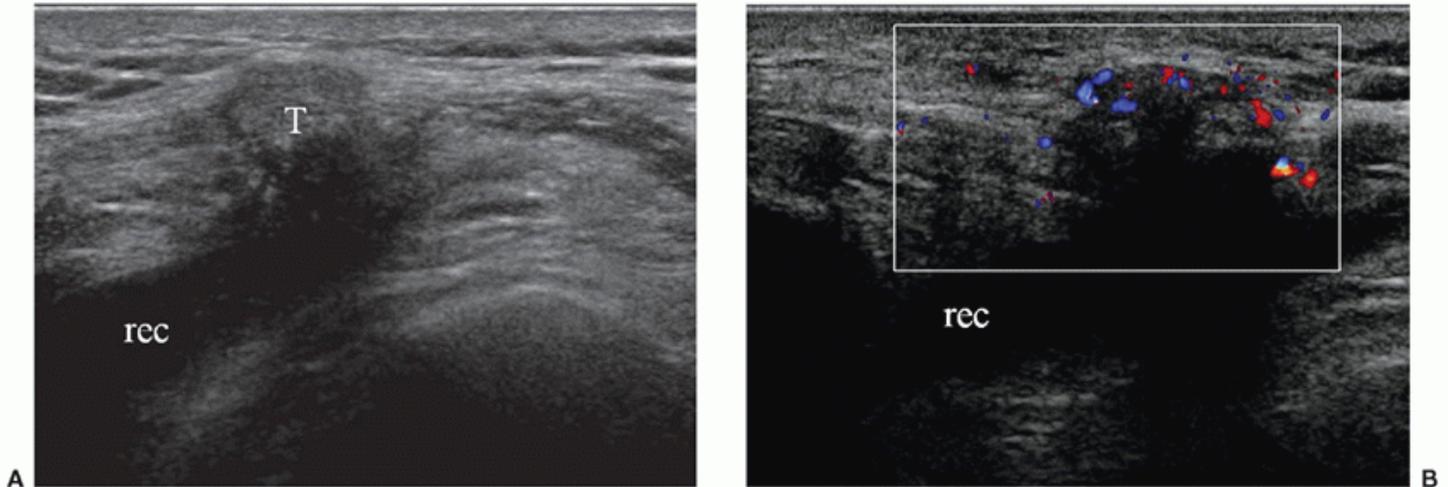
Transverse scan of the parapatellar recess (rec) of a patient with gout. A: A palpable tophus close to the parapatellar recess is inhomogeneous, hyperechoic, and casts strong acoustic shadowing (T). B: Peripheral hyperemia on color Doppler confirms the presence of inflammation.
